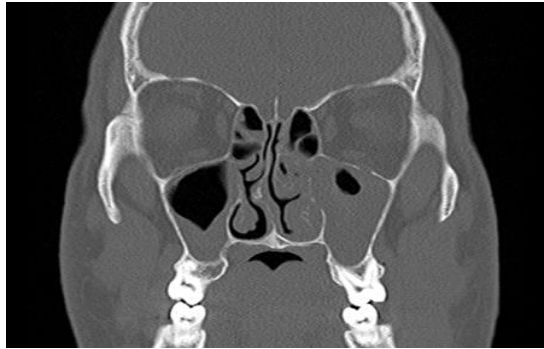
CT features of chronic maxillary sinusitis. Coronal CT image demonstrating bilateral maxillary sinus mucosal thickening with partial opacification and associated ostiomeatal complex narrowing, consistent with chronic inflammatory changes. (CT Image provided by Dr. A. Gharibyan)
